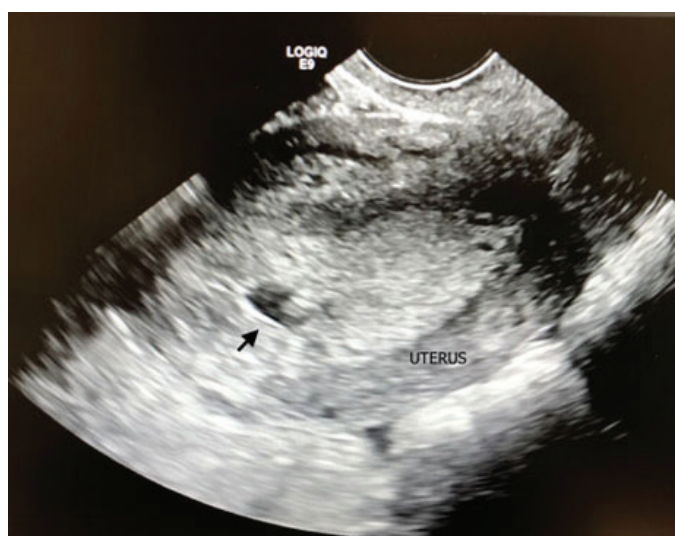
Transvaginal ultrasound of the uterus in the sagittal plane. The black arrow is aimed toward the intrauterine contents. The posterior wall of the uterus is marked "UTERUS."
